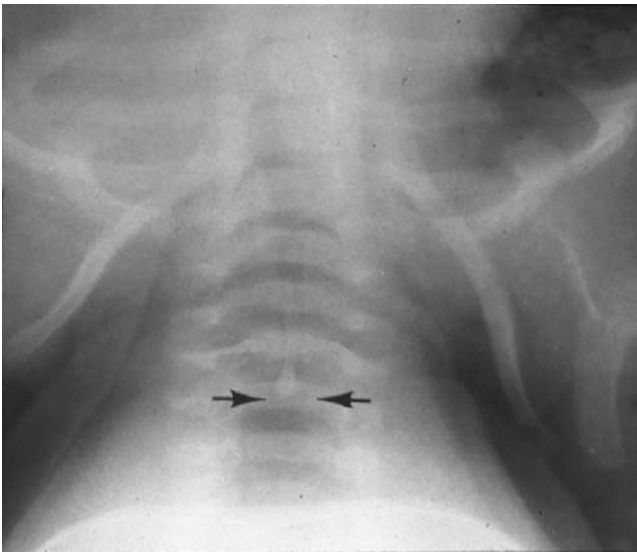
Foreign body (glass) oriented in an anteroposterior (AP) position in the trachea as evidenced on AP radiograph.
